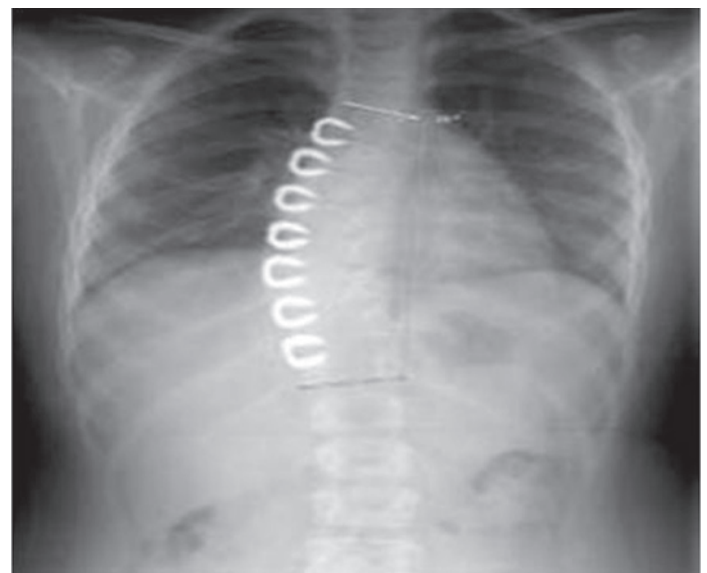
X-ray of a patient who has undergone vertebral stapling for progressive moderate scoliosis. Staples have been placed on the convexity (outside) of the curve without performing a fusion.
